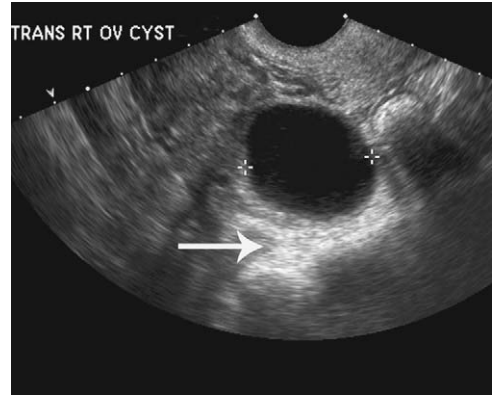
Follicular cyst. Transvaginal ultrasound of a follicular cyst (calipers), which resolved on follow-up 2 months later. The cyst is anechoic, thin-walled, and shows posterior acoustic enhancement (arrow).
